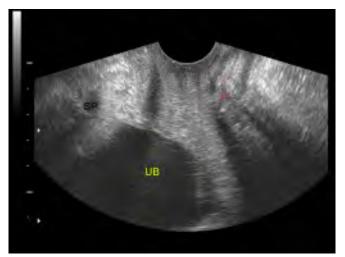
Ultrasound image as obtained with an ideal transducer placement. Note the hypoechoic symphysis pubis (SP) with an echogenic inferior margin, the urinary bladder (UB) and the vagina (V). The normal urethra is seen as a markedly hypoechoic, long structure and the bladder neck is closed
